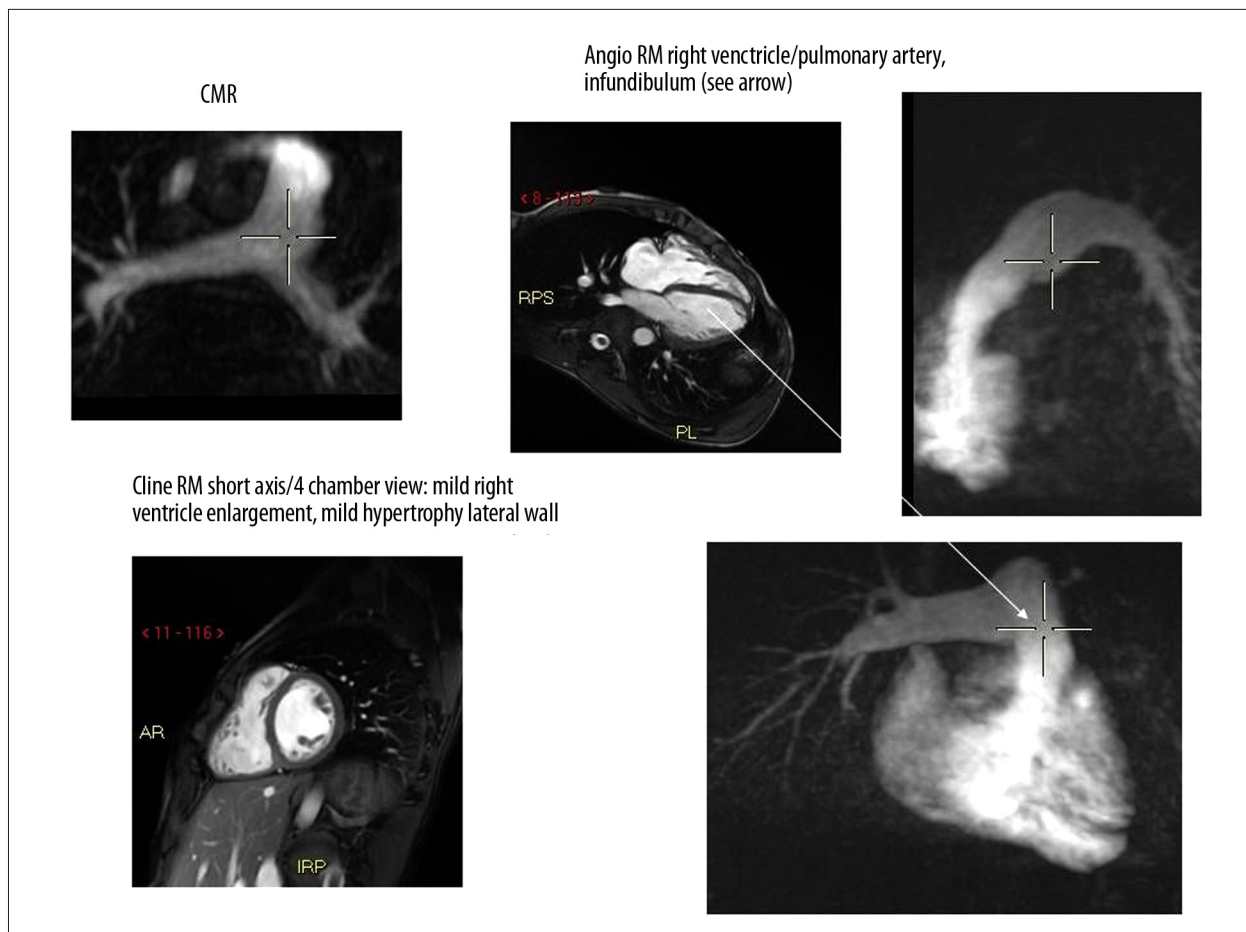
Cardiac MRI reveals slight dilation with hypertrophy of the right ventricle and shows the infundibular region of the right ventricular outflow tract.
